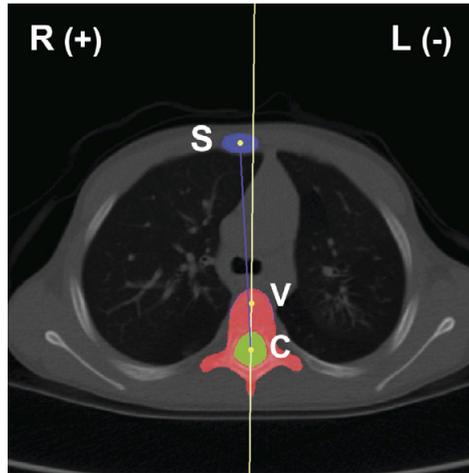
CT slice at level T5 in the transverse plane. Vertebral rotation was defined as the angle between the mid-sagittal axis (line between the center of the sternum (S) and the center of the spinal canal (C)) and the longitudinal axis of the vertebra (line through the anterior half of the vertebral body (V) and spinal canal (C)).
